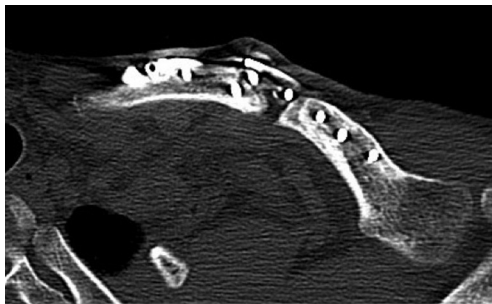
Pre-operative CT scan demonstrating the left clavicular non-union.
